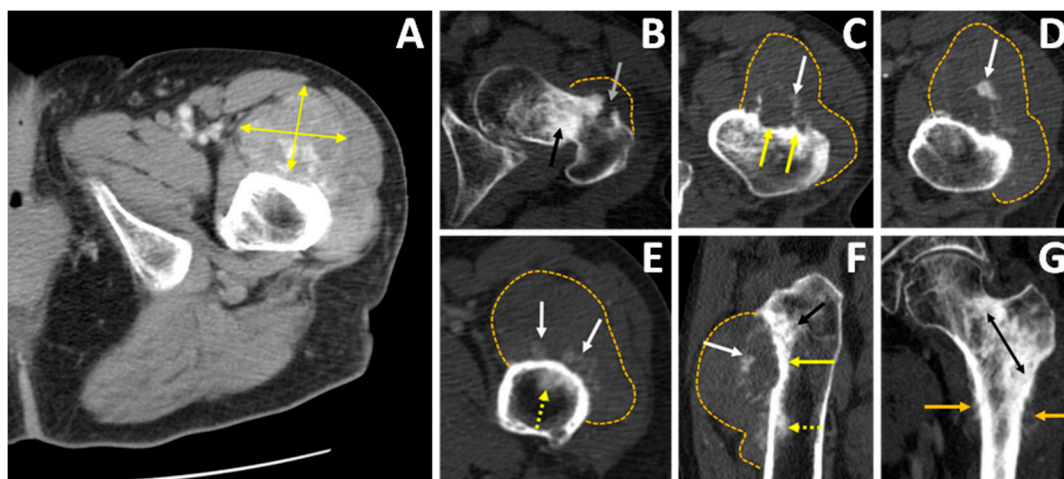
Symptomatic major lesion: a large, aggressive tumour mass, residing on the superficial (periosteal) aspect of the anterior proximal left femur, spreading superficially alongside the anterior periosteal surface of the proximal femur, transaxial section, contrast-enhanced CT, soft-tissue windowing (A); contrast-enhanced CT, bone windowing, transaxial sections at different levels of the proximal femur (B-E); contrast-enhanced CT, bone windowing, sagittally and coronally reformatted sections (F-G). Markings: tumour mass (orange dashed line); intramedullary reactive sclerosis or osteoblastic tumour proliferation (black arrows); cortical destruction (grey arrow); superficial cortical erosions (yellow arrows) with nearby and distant tumoural calcifications (white arrows); intramedullary tumour invasion (dashed yellow arrows); spiculated periosteal reactions (orange arrows).
